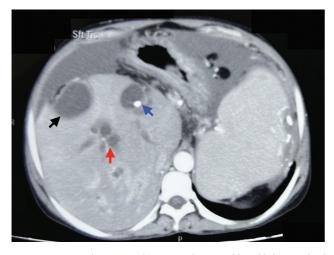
Computed tomography image showing dilated biliary radical (red arrow) with plastic stent in situ (blue arrow) and cholangitic abscess (black arrow).
